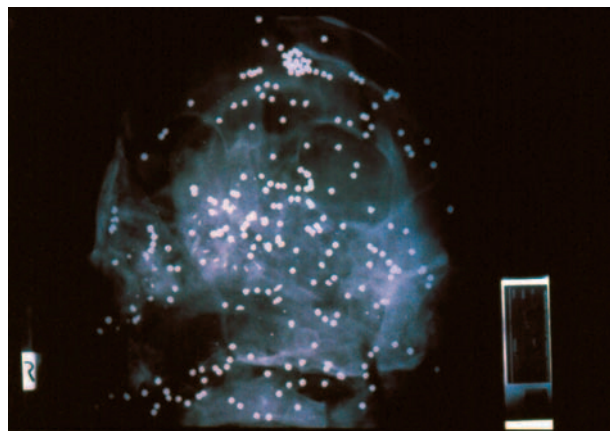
In this case, the pellets did not exit and the scalp remained intact. The X-ray shows extensive cranial fracture. Many pellets are seen to line the inner table.
